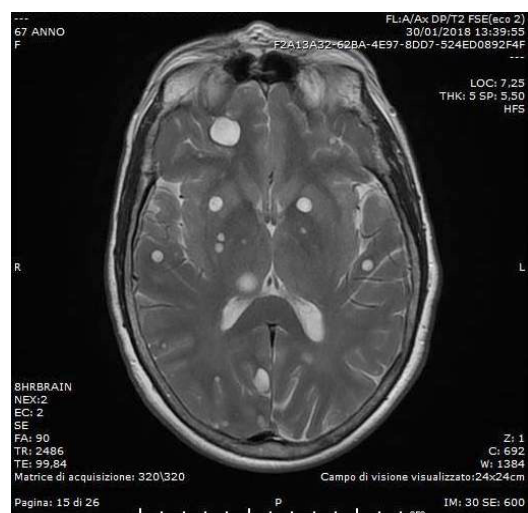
Multiple cystic lesions in axial T2-weighted MRI.
